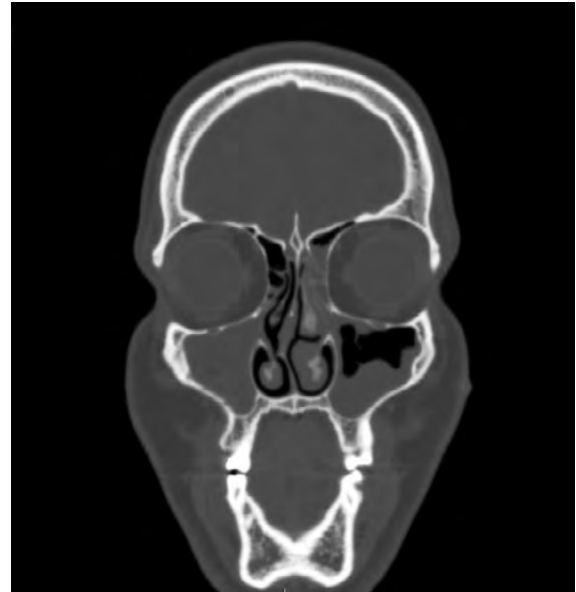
CT of maxillary sinuses following treatment, showing reduced opacification compared to Figure 2.
